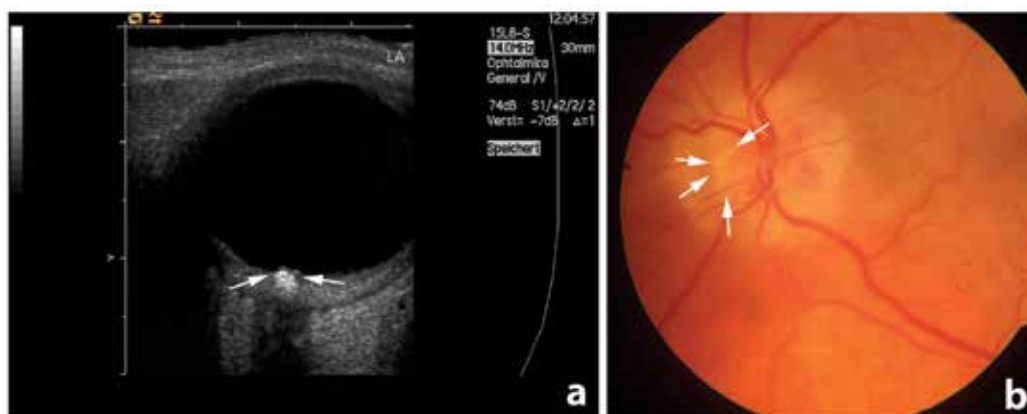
Optic disc drusen seen in funduscopy and high-resolution ultrasound: (a) B-mode sonography: calcific dispositions in the optic nerve head representing optic disc drusen. (b) Funduscopy: nasally located superficial drusen, blurred rim of optic disc, optic disc edema and hyperemia
